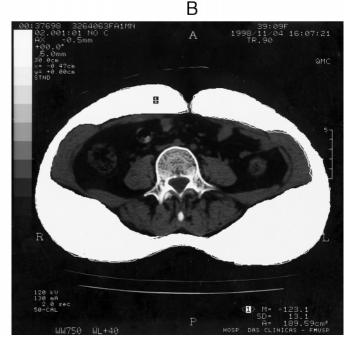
Computed tomography showing cross-sectional abdominal areas at umbilicus level in two patients demonstrating variation in fat distribution. A, Visceral type (49-yr-old female, 23.1 of BMI, visceral fat area: 146 cm²; subcutaneous fat area, 115 cm²; V/S ratio, 1.27). B, Subcutaneous type (40-yr-old female, 24.0 of BMI, visceral fat area: 60 cm²; subcutaneous fat area, 190 cm²; V/S ratio, 0.31).
